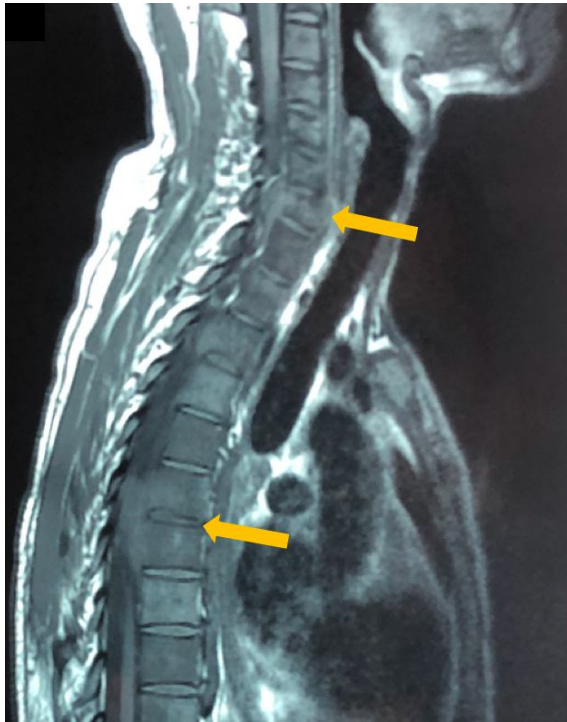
Spinal magnetic resonance imaging (MRI) suggesting a multifocal (cervical and lumbar) spondylodiscitis.
